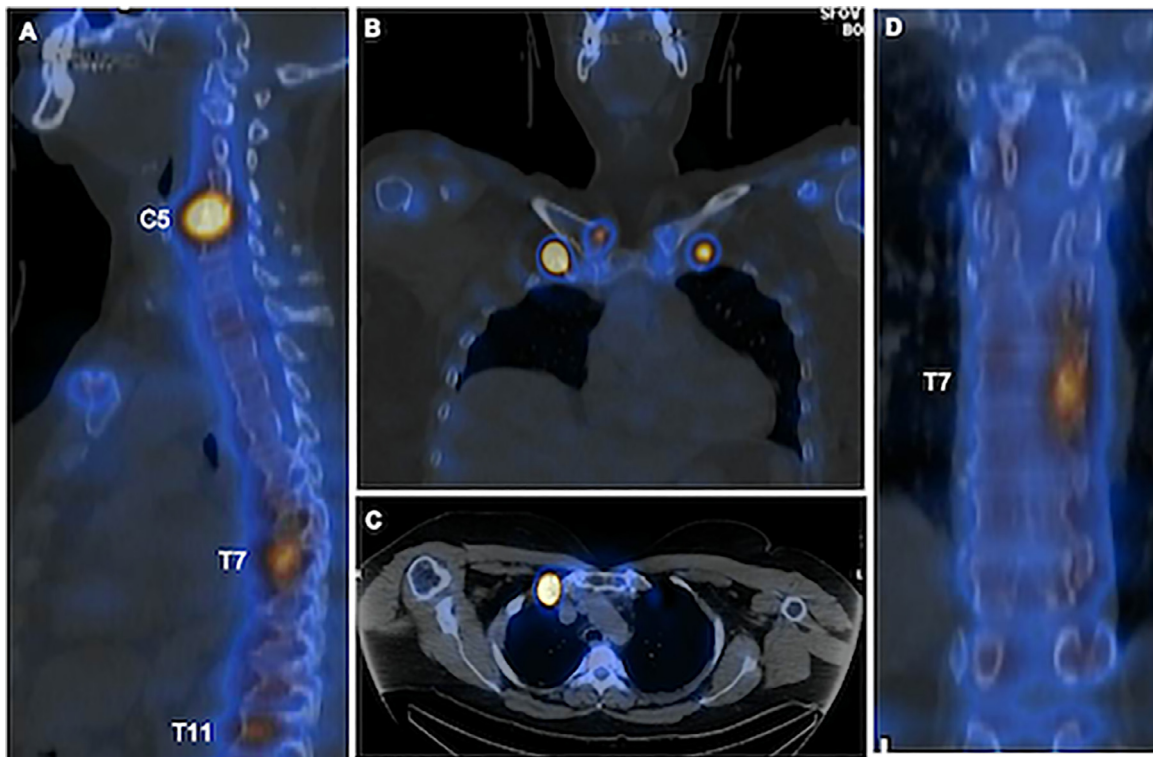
Panel A shows a sagittal cut, Panel B shows a coronal cut, Panel C shows an axial cut, and Panel D shows a coronal cut of a whole-body Bone Single-photon Emission Computed Tomography (SPECT) scan showing increased activity in the C5, T7 and T11 vertebral bodies, as well as increased activity in bilateral 1st rib costochondral joints and right sternoclavicular joint.
